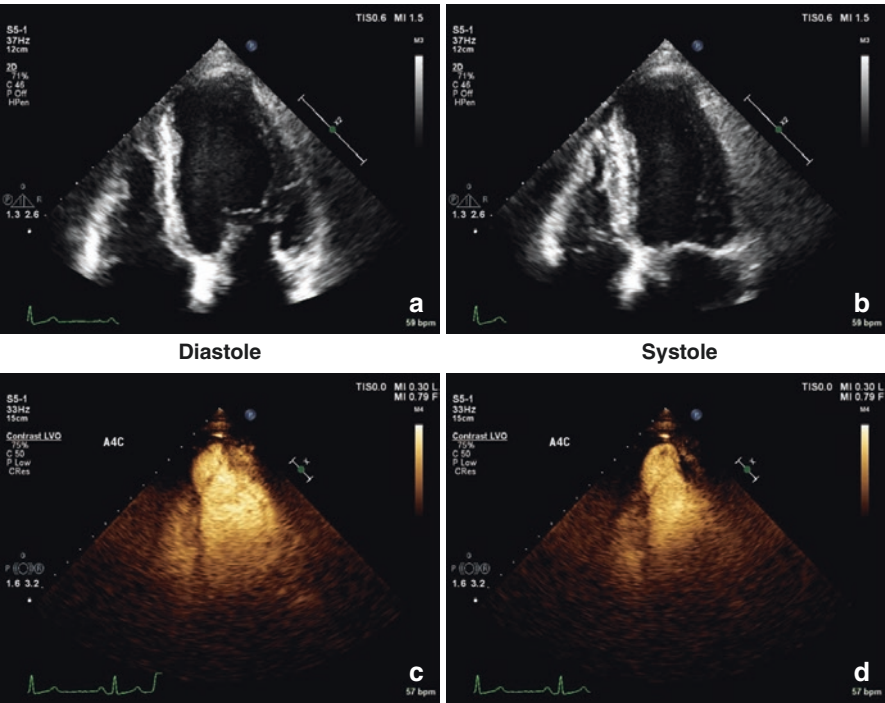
(a–d) Apical four-chamber view in diastole (a) and systole (b) and with echo contrast, respectively (c, d), showing a large apical AMI with a large apical aneurysm with no clot
